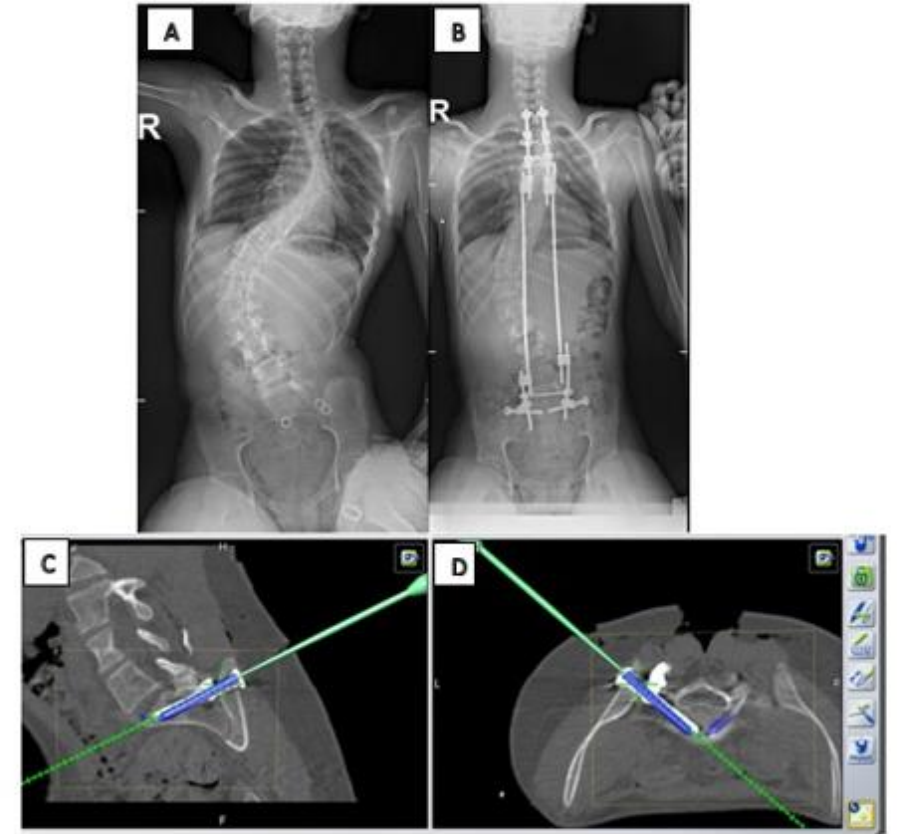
Minimally invasive fusionless technique for neuromuscular scoliosis using iliosacral screws with preoperative trajectory planning and intraoperative CT based navigation. A: preoperatively, B: Postoperatively, C and D Intraoperative fusion of the preoperative CT images with the screw planning (blue lines) and the CT navigation images. The green line present the probe with whom we make the trajectory of the planned screws.
